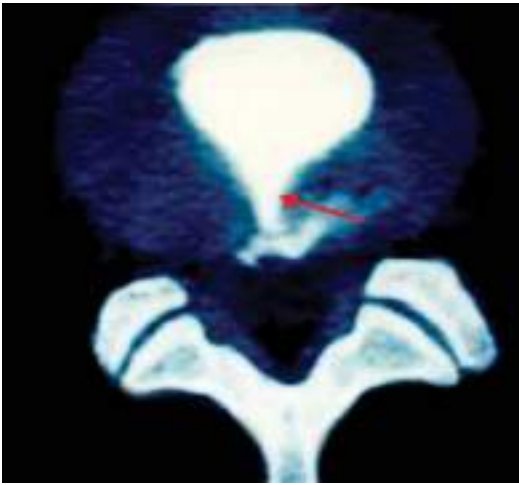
CT scan after discography showing the annular tear (red arrow)
